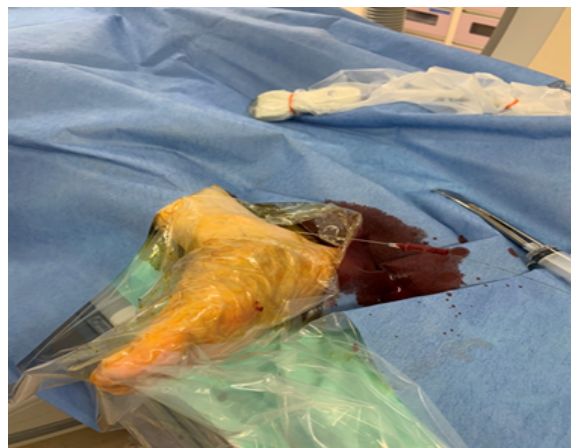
Ultrasound-guided posterior tibial artery puncture.
